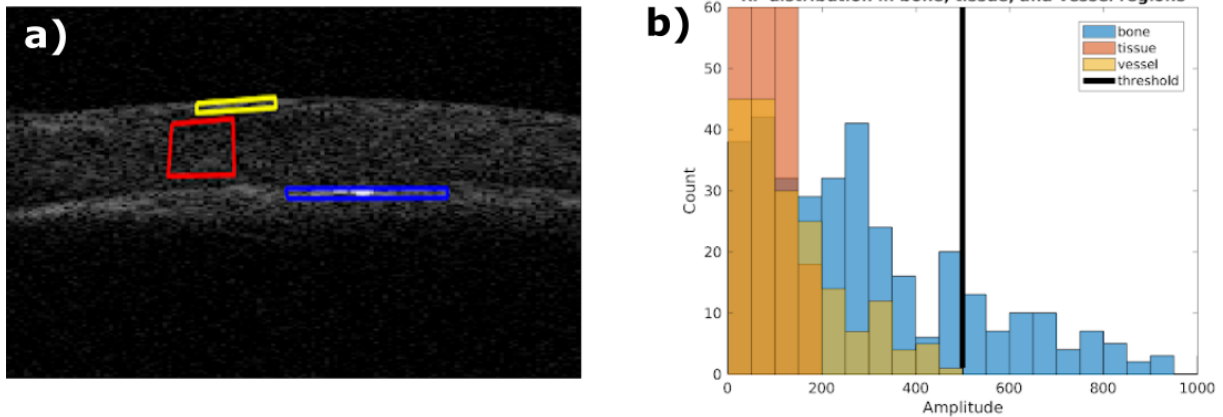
a) Channel data for one ultrasound frame with three regions of interest (bone, tissue, and vessel). (b) Histogram showing amplitude distribution in three regions of interest. Bone (blue) has the highest amplitude scatterers, followed by the top vessel (yellow). Tissue (red) has the lowest amplitudes.
